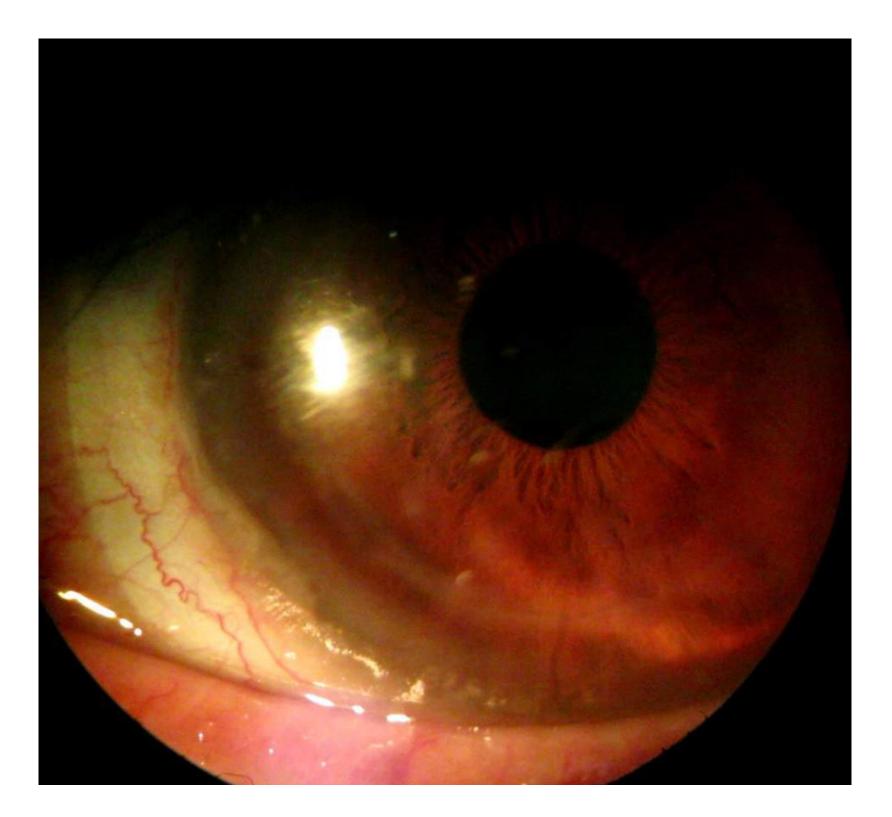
An ideal fitting relationship was achieved. (Lens CT: 350 microns)
